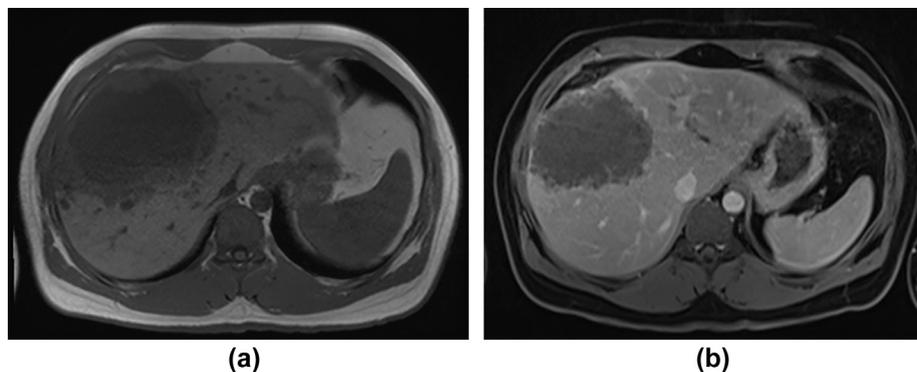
(a) T1-weighted MRI image demonstrating central low T1 signal within the cystic component and intermediate T1 signal at the lesion margin. (b) After intravenous contrast medium administration, fat-saturated imaging demonstrates minimal peripheral enhancement (thought to be related to the presence of fibro-inflammatory tissue).
